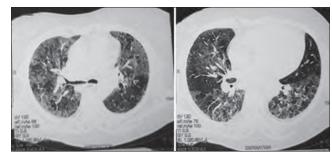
HRCT of the patient in inspiration (left) and expiration (right)
